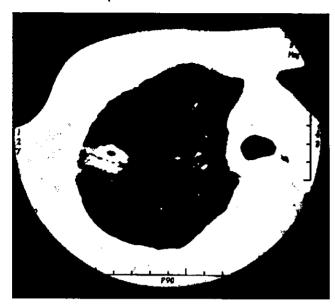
Chest computed tomography scan on day 61. A nodular lesion with cavitation was seen in the right upper lobe (S₃). The ground-glass like lesion at the periphery was supposed to be bronchiolitis obliterans organizing pneumonia.
